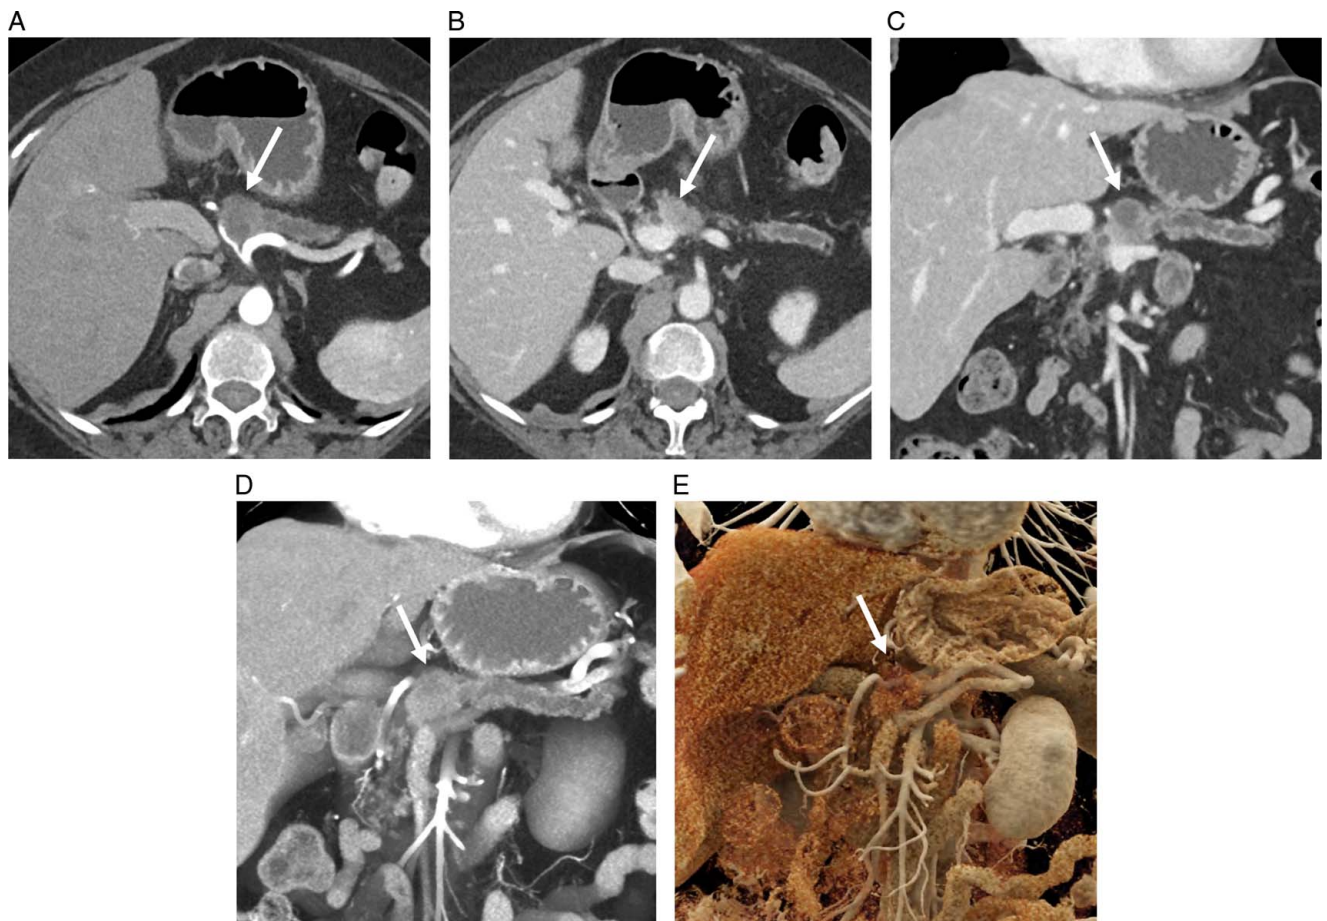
A 76-year-old woman with borderline resectable pancreatic ductal adenocarcinoma. Axial intravenous (i.v.) contrast-enhanced computed tomography (CT) images in the arterial phase (A) and portal venous phase (B), and a coronal i.v. contrast-enhanced CT image in the portal venous phase (C) demonstrated a hypoenhancing mass arising from the neck of the pancreas (arrows) with associated pancreatic duct dilatation and atrophy of the body and tail. The tumor abutted the common hepatic artery, splenic artery, portal vein, and superior mesenteric vein, and was staged as borderline resectable. Volume rendering (D) and cinematic rendering (E) of coronal i.v. contrast-enhanced CT images in the arterial phase may improve appreciation of tumor contact (arrow) with adjacent vessels. The patient underwent neoadjuvant chemotherapy and subsequent Whipple resection.
